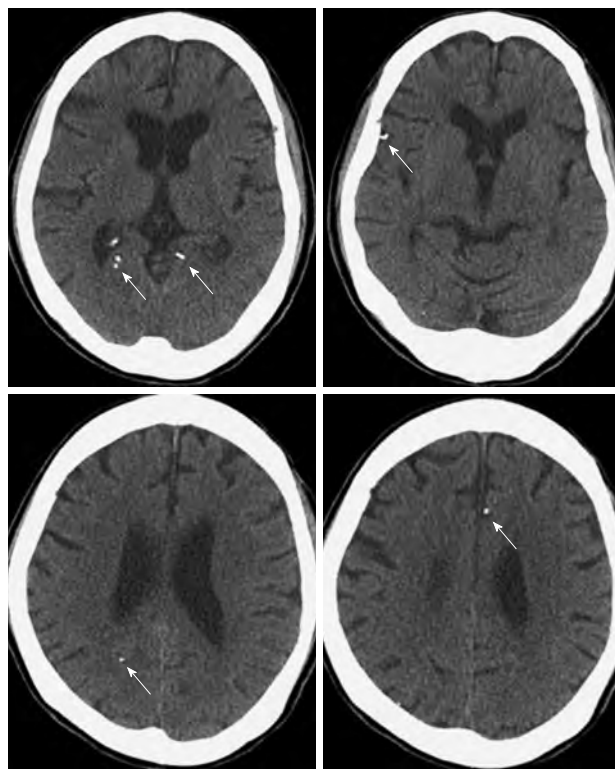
Non-contrast brain computed tomography showing multiple high attenuation lesions (arrows). The multiple high attenuation lesions are emboli of the Histoacryl-Lipiodol mixture. The high attenuation lesions were seen in the frontal lobe and the parieto-occipital lobe.
